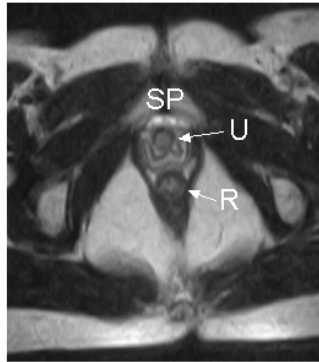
Axial view of urethral sphincter and urethra on T2-weighted image of healthy male volunteer. SP, symphysis pubis; U, urethral sphincter and urethra; R, rectum.
